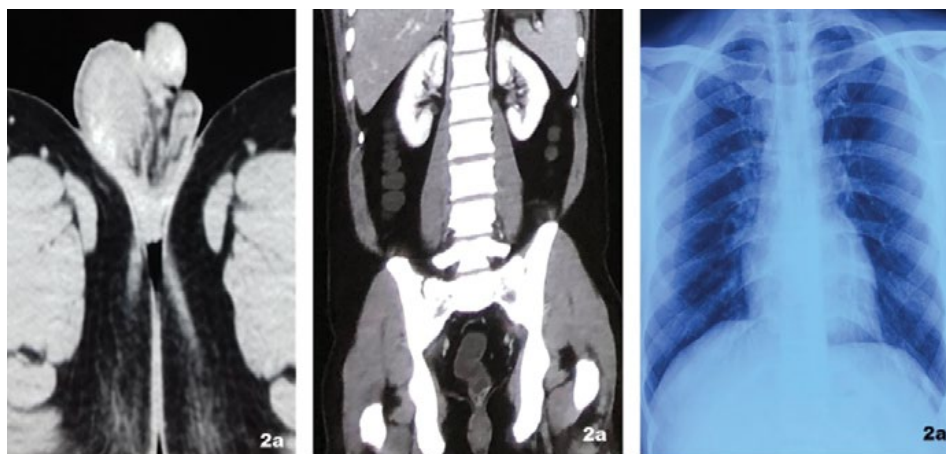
CT scan of scrotum showing Rt. Testicular mass (a), CT of the retroperitoneal shows no evidence of secondary's, c. Chest radiography shows no evidence of metastasis (b).
